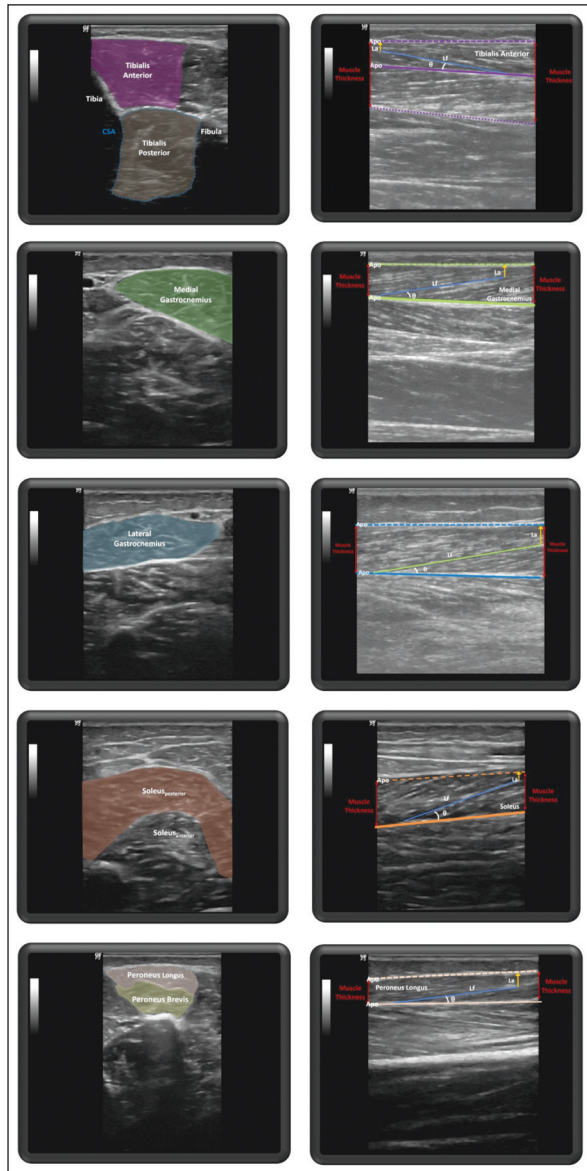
Ultrasound images of muscles measured at rest. Apo: Aponeurosis; CSA: Cross sectional area; MT1: Proximal muscle thickness; MT2: Distal muscle thickness; Lf: Longest fiber length in the visible section by ultrasound; La: Shows the distance from the fiber distal end point to the superficial aponeurosis. The pennation angle was measured (θ) as the angle between the fascicle (green line) and its deep aponeurosis (blue line). The muscle thickness was measured between the superficial aponeurosis and the deep aponeurosis (blue dashed line) for proximal and distal side. The muscle thickness $(MT1+MT2)/2$ and the fascicle length $(Lf+La/\sin\theta)$ were calculated.
